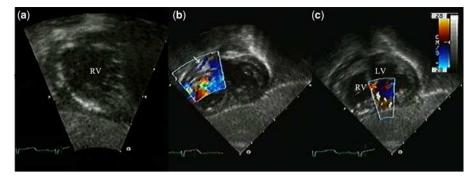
Subxiphoid short-axis view: (a) endomyocardial fibroelastosis of the diaphragmatic wall and of the lateral free walls of the right ventricle (RV); (b) colour Doppler shows diastolic reverse flow in the proximal right coronary artery (arrow); (c) colour Doppler shows the intercoronary collateral circulation between the circumflex and the right coronary artery $(RV = right \ ventricle)$; $LV = left \ ventricle)$.
